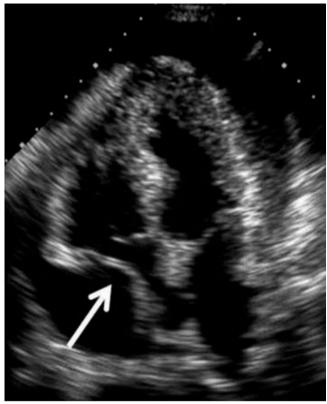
Echocardiogram showing RA chamber inversion/collapse (*arrow*)
